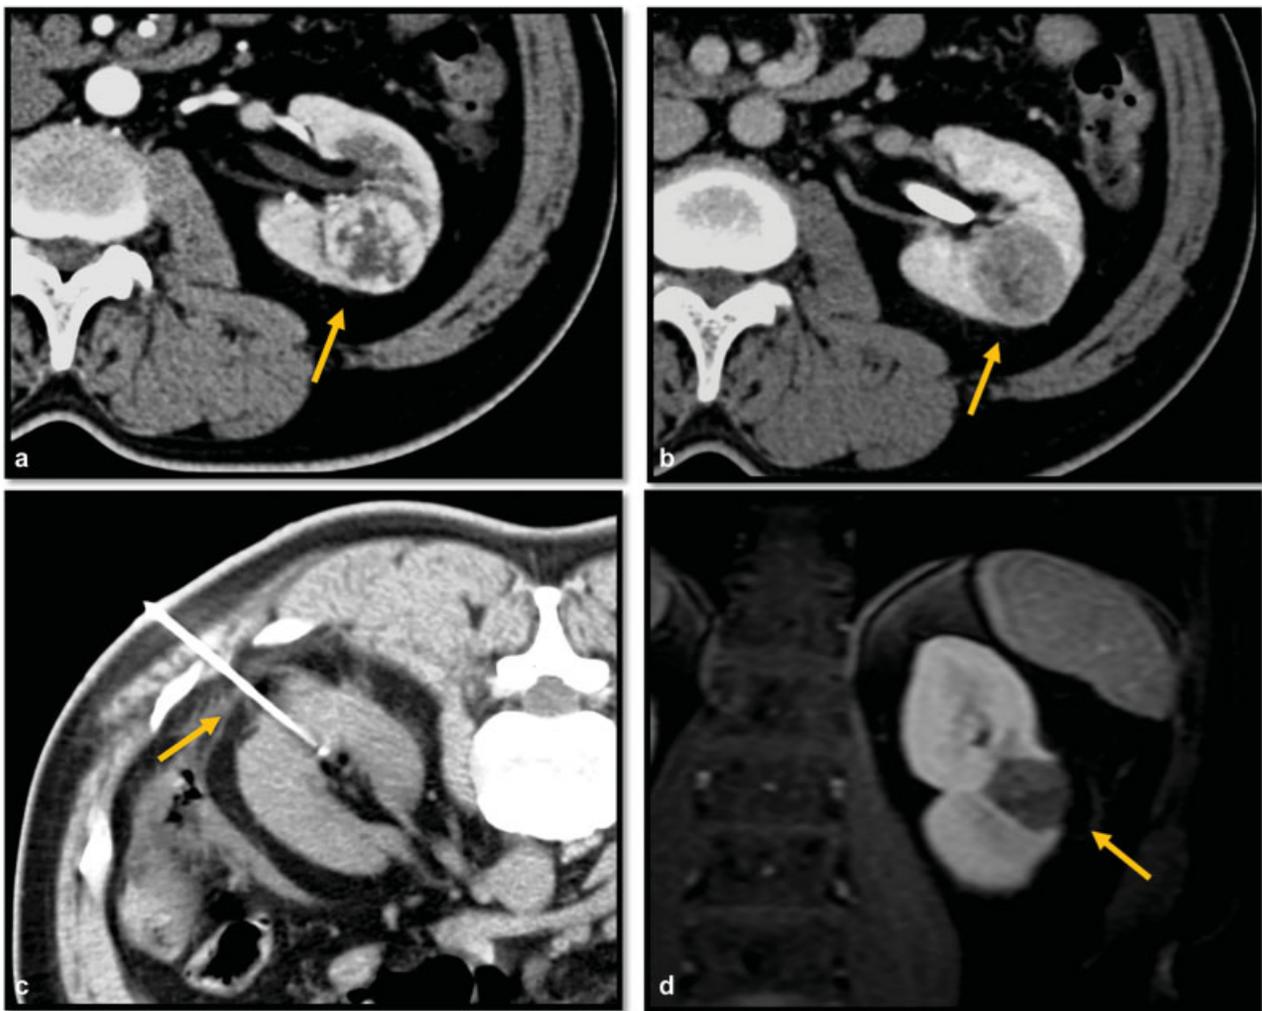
A 57-year-old man with 3.3 cm *endophytic*, hypervascular, clear cell renal cell carcinoma (RCC) in the left kidney (*arrow*). Preablation CT shows typical clear cell corticomedullary hyperenhancement (a) and nephrographic washout (b). One of two microwave antennas was placed into the RCC under CT guidance (c). Postprocedure T1-weighted, fat-saturated, contrast-enhanced MRI shows complete ablation with smooth margins with residual enhancing tumor (d).
